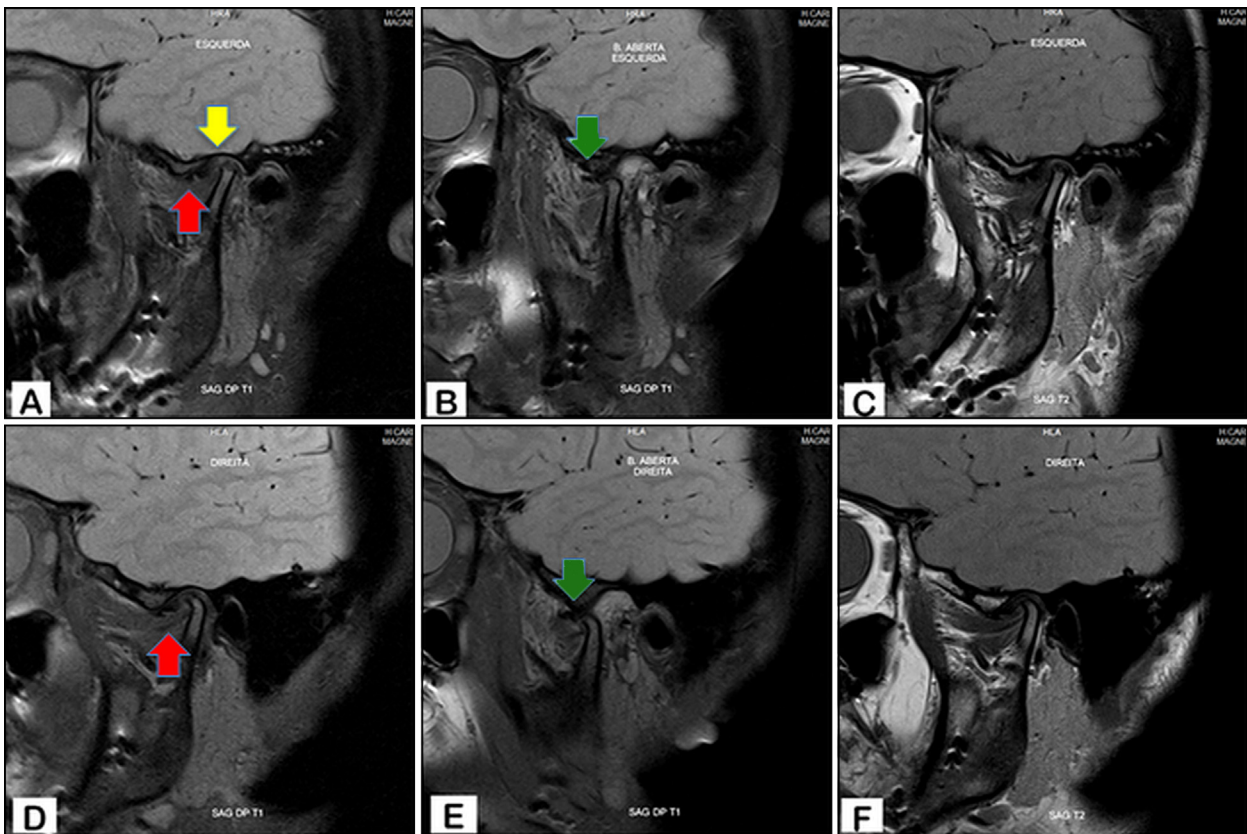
A-C, Posttreatment (2 years after surgery) sagittal oblique TMJ left and D-F, right turbo spin echo MRI. T2-weighted closed-mouth position proton density shows the left and right articular discs in frank anterior displacements (*red arrows*) and left condyle and disc with degenerative features (*yellow arrow*). Open-mouth positions depict no disc reduction on the right (E) or left (B) sides (*green arrows*). Left T2-weighted closed-mouth position (C and F) shows no intracapsular hypersignal.
